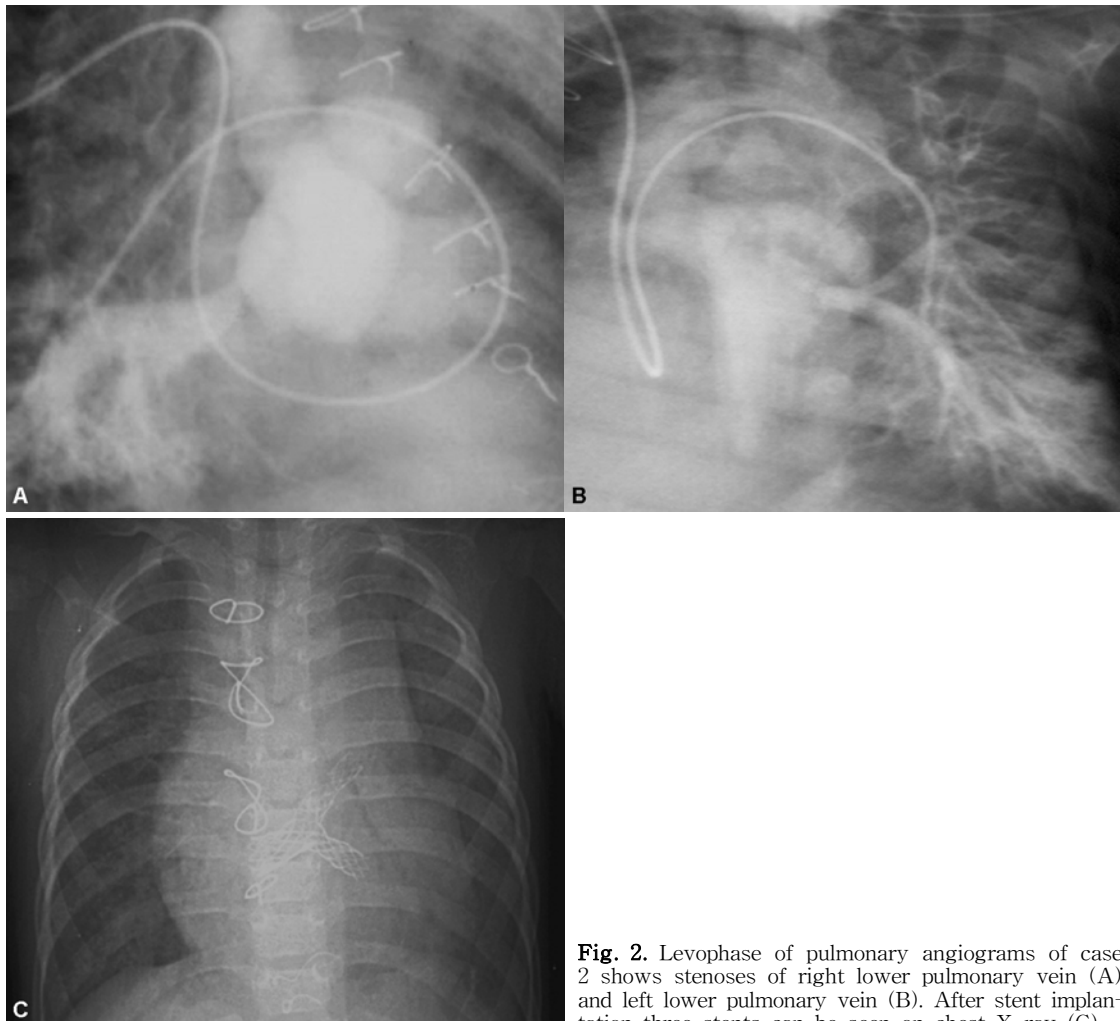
Levophase of pulmonary angiograms of case 2 shows stenoses of right lower pulmonary vein (A) and left lower pulmonary vein (B). After stent implantation three stents can be seen on chest X-ray (C).
